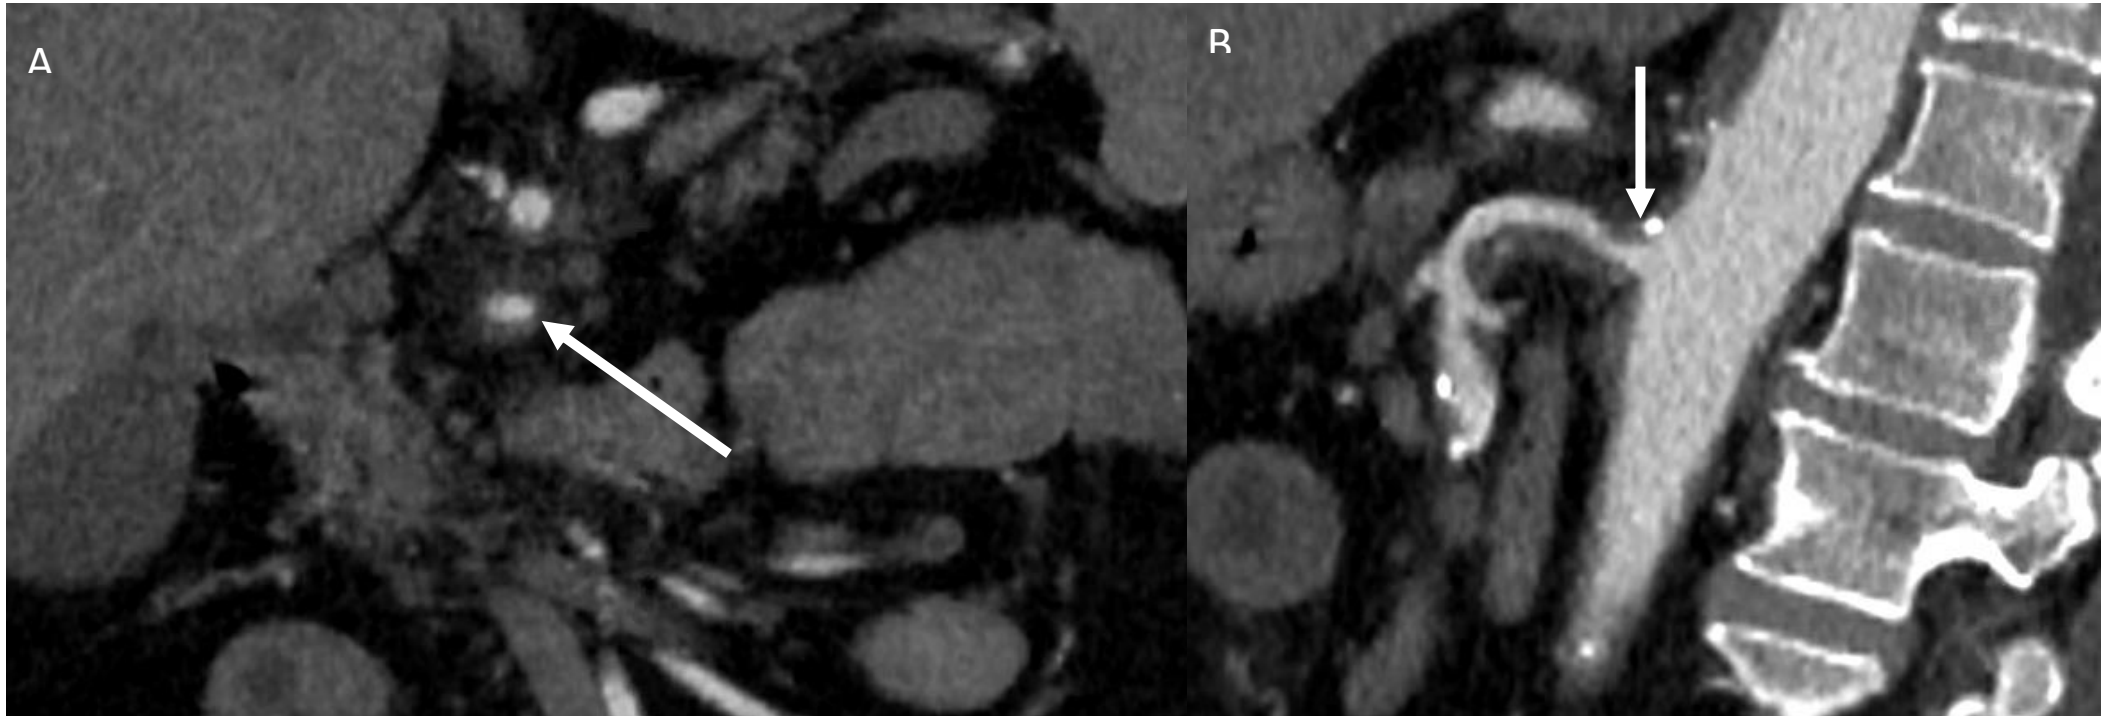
Abdominal CT-scan of a 56 years old patient with AMI showing an incomplete occlusion of the S0 segment of the SMA (arrow) : (A) coronal view and (B) sagittal view
